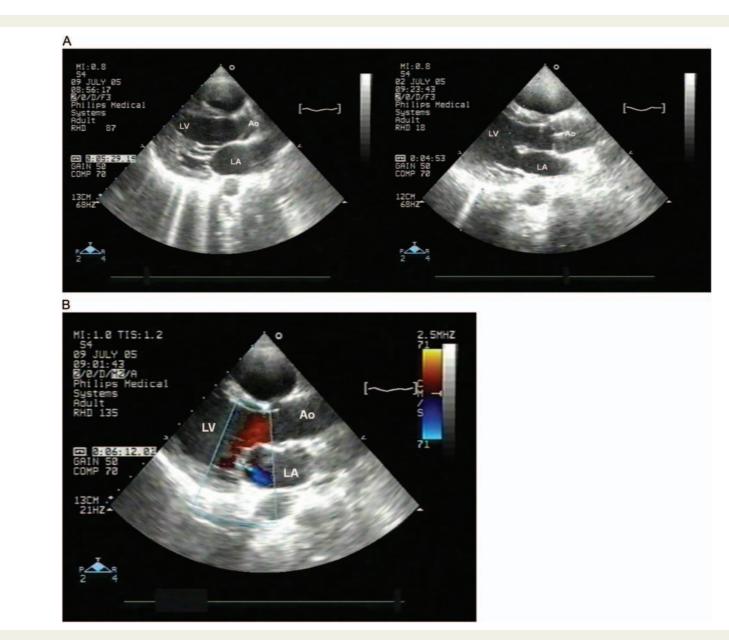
Figure I (A) Trans-thoracic echocardiography: parasternal long-axis view in a case meeting the reference criteria. Morphological features were in the presented case: (i) prominent thickening, and shortening of chordal structures (left panel), and (ii) marked thickening of the margins (right panel). Ao, aorta; LA, left atrium; LV, left ventricle. (B) Trans-thoracic echocardiography: parasternal long-axis view in a case meeting the 'simplified' criterion (i.e. MR jet length ≥2 cm). Ao, aorta; LA, left atrium; LV, left ventricle.
